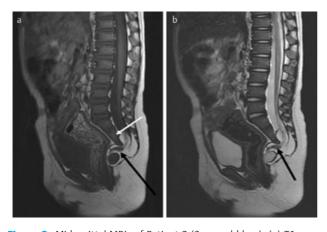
Midsagittal MRIs of Patient 1 (11-year-old girl). (a) T1-weighted image; (b) T2-weighted image. Partial distal sacral agenesis (black arrow) is present. A large cystic mass (white arrow) is present between the uterus and the sacrum.
